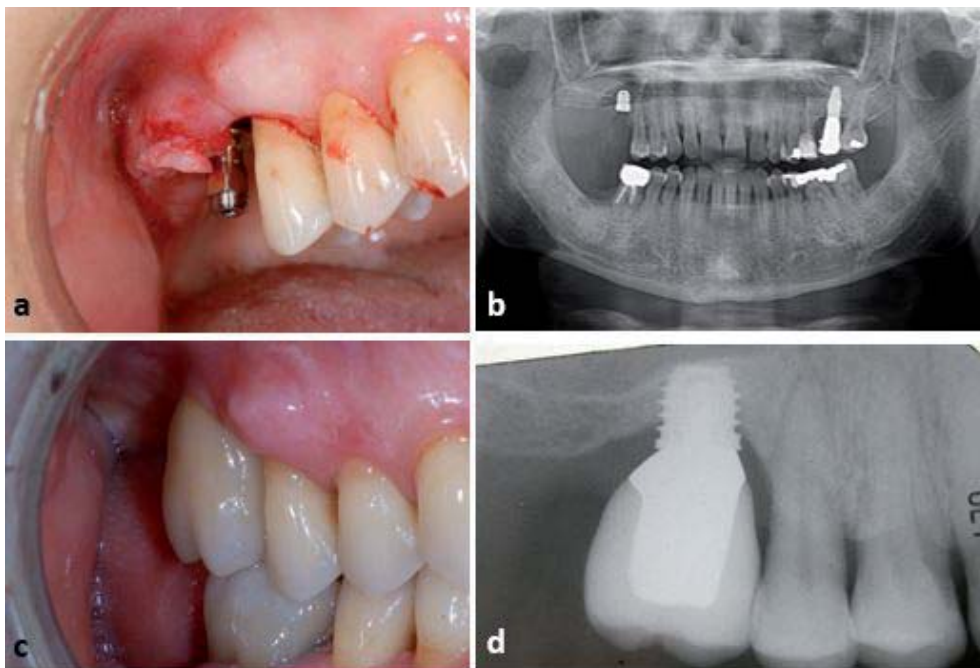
A – intra-operative surgical step of implant placement; B – orthopantomography after implant insertion; C – definitive crown restoration; D – periapical radiography of final restoration immediately after placement.
